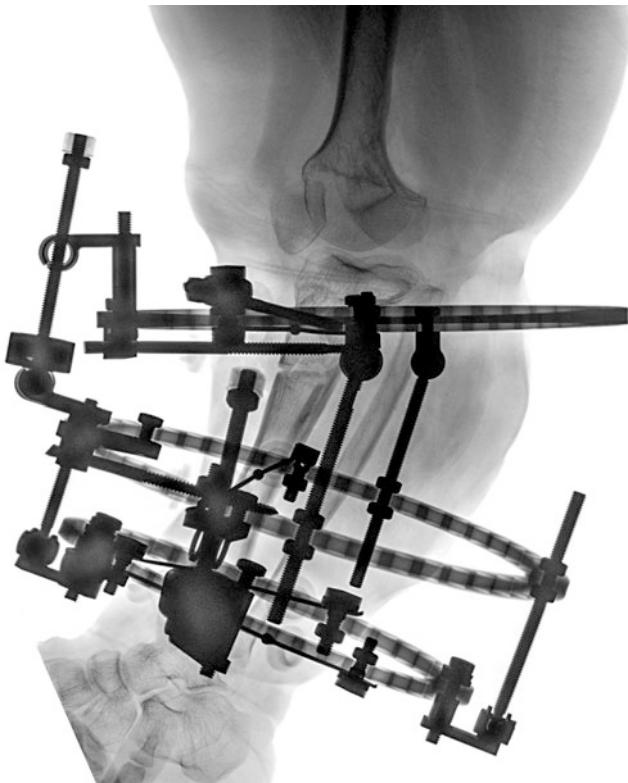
Lateral radiograph of the tibia after proximal tibial osteotomy and application of TrueLok (Orthofix) circular external fixator. The frame configuration for correction of recurvatum included a proximal ring attached to the proximal tibia with one horizontal olive wire and two half pins. The proximal ring was connected with two posteriorly located hinges and anterior angular distractor to the middle ring. The middle tibial ring was secured to the middle tibia with one medial face olive wire and one half pin. For future distal tibial varus deformity correction, the middle ring was connected via two lateral hinges and medial angular distractor to the distal ring which was secured to the distal tibia with two cross wires. Stable SSEP recordings were documented throughout the surgery. Note that the fibula was attached to the frame only distally for gradual translation simultaneously with correction of tibial recurvatum
